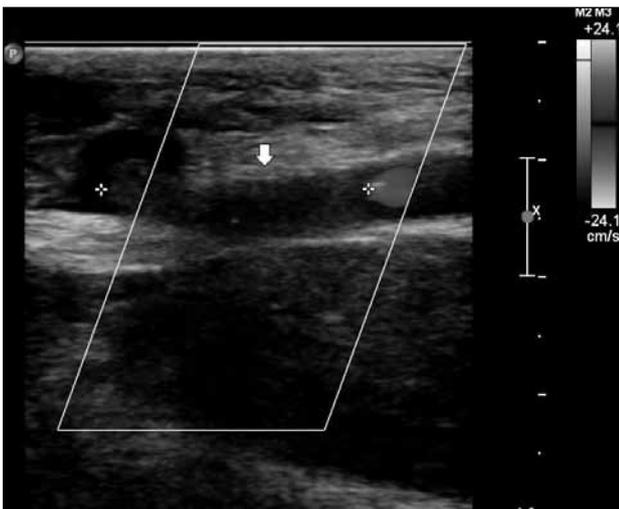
Doppler ultrasonography shows cessation of flow of brachial artery with hypoechoic intraluminal thrombus (arrow) and discontinuity of brachial artery.
